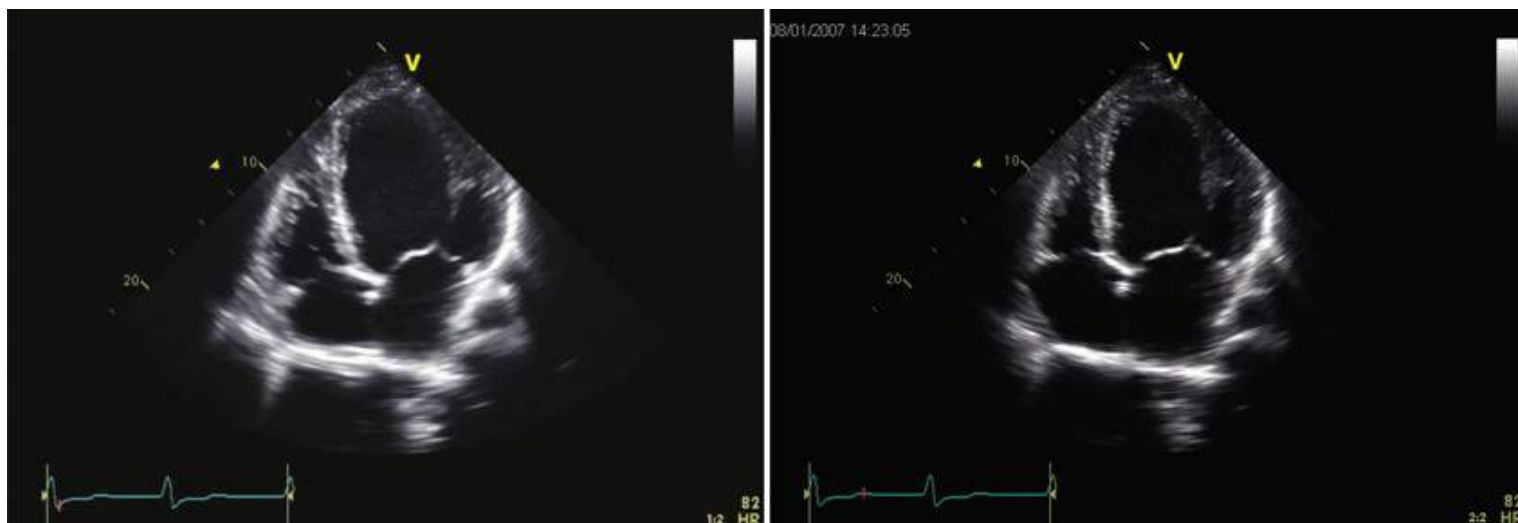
Echocardiogram in a patient with dilated cardiomyopathy. The end-diastolic frame (left) and end-systolic frame (right) in a 40-year-old man with severe DCM (ejection fraction < 20%) are shown. Note the globular LV shape, typical of advanced DCM. Despite the severe reduction in LV ejection fraction, he had only mild symptoms, attributable, in part, to preservation of stroke volume because of the marked increase in LV end-diastolic volume.
